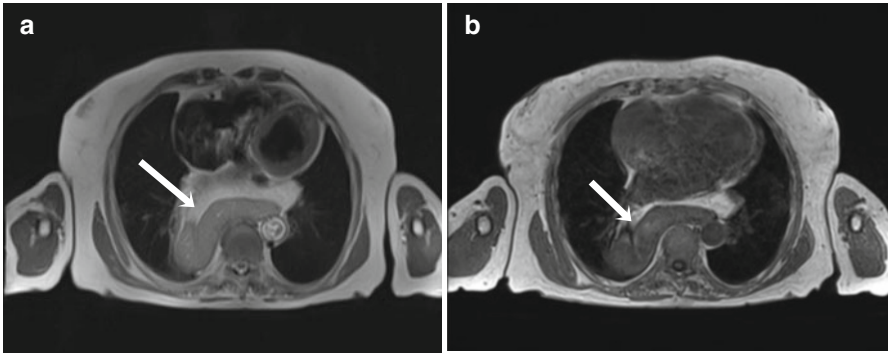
Thoracic stomach (*arrow*) not causing clinical discomfort. There is a large opening in the diaphragm without signs of incarceration. (a) T2-weighted HASTE image; (b) fat-saturated axial VIBE image
